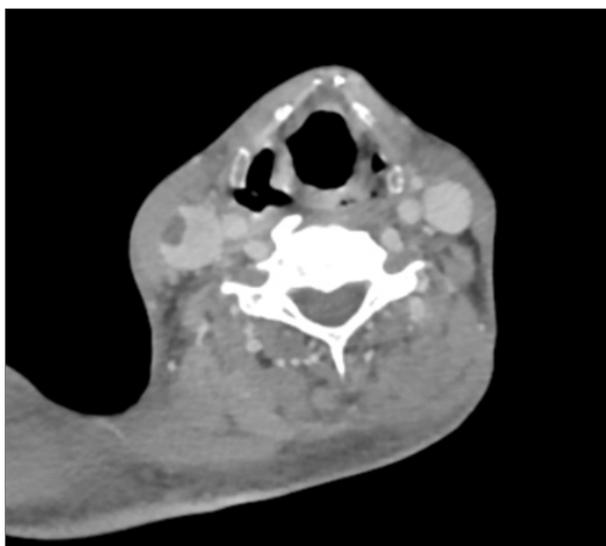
CT neck revealing thrombus in the right Internal Jugular Vein (Black arrow)
